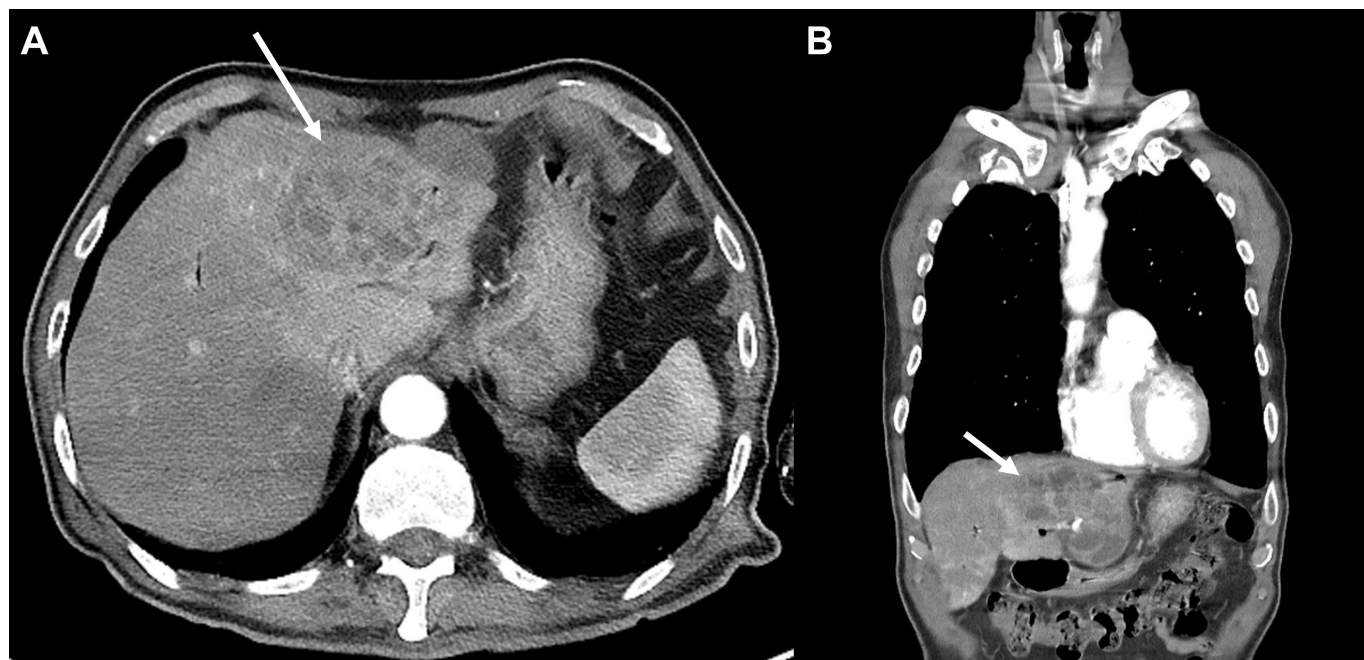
Contrast-enhanced computed tomography scan of the 8.3 cm liver abscess in segments 2, 3, and 4. (A) Horizontal view; (B) coronal view.
